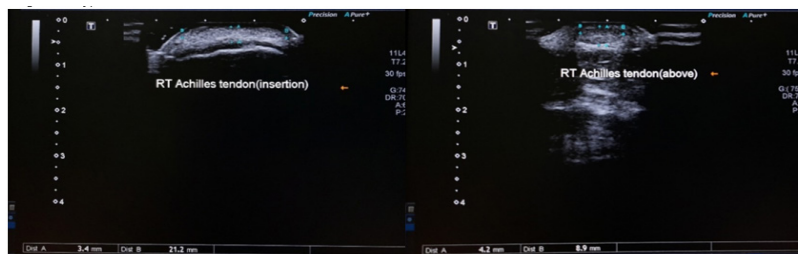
Linear MSK ultrasound of the same patient. The right AT measurements (thickness at the AT insertion into the calcaneus and above insertion: 3.4 mm and 4.2 mm, respectively; the width at the AT insertion into the calcaneus and above insertion: 21.2 mm and 8.9 mm, respectively).
